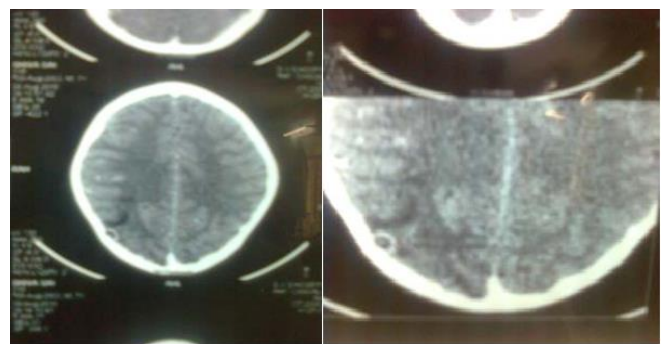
a. CT Scan showing single lesion NCC. b. Enlarged view
